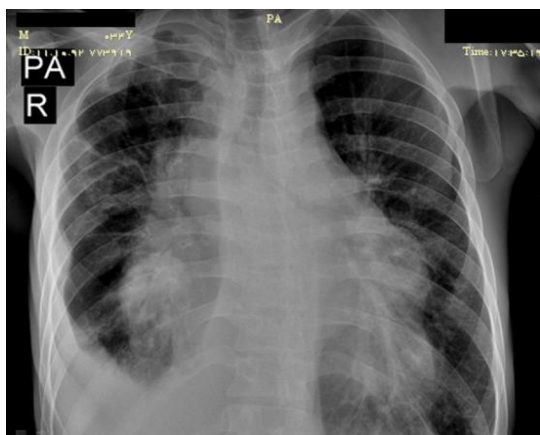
Postero-anterior chest radiograph of a patient with mediastinal NEC, showing the right mediastinal mass and the right-sided pleural effusion
